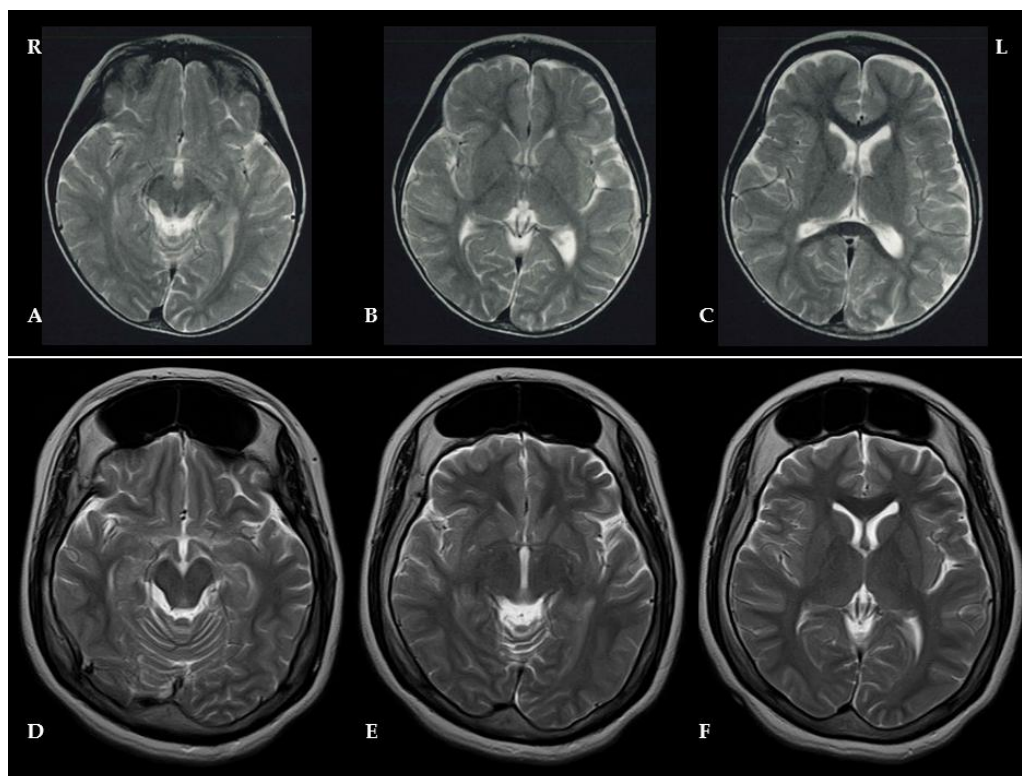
Brain MRI T2-weighted images were obtained at ages 2 (A/B/C) and 16 (D/E/F). At age 2, no significant abnormalities were detected; however, at age 16, there was prominent thickening of the frontal bone, indicative of hyperostosis frontalis interna (HFI). Additionally, bilateral enlargement of the frontal sinuses was observed, suggesting extensive involvement of the anterior cranial vault. The high-resolution T2-weighted imaging facilitated precise visualization of cranial abnormalities, thereby supporting the diagnosis of HFI and underscoring the atypical manifestation of macrocephaly in this case of Rett syndrome.
